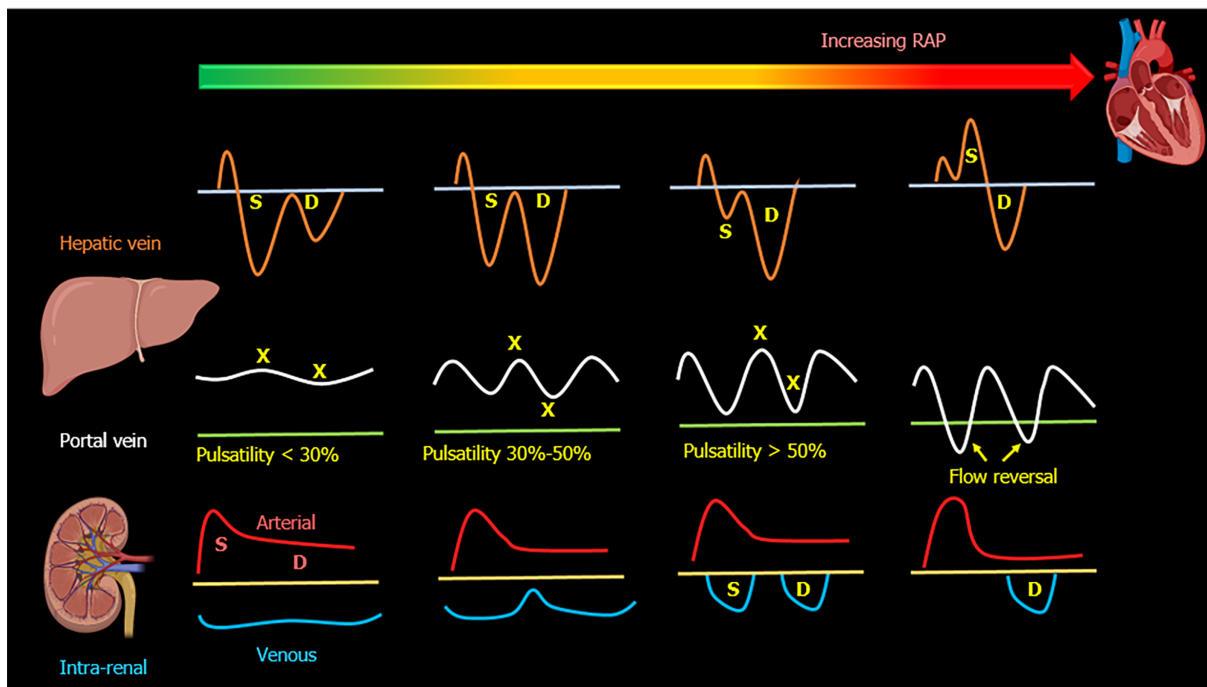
Transformation of the hepatic, portal, and intra-renal Doppler waveforms with increasing right atrial pressure. Asterisks on the portal waveform represent the highest and lowest points during a cardiac cycle used to calculate pulsatility fraction. RAP: Right atrial pressure.
